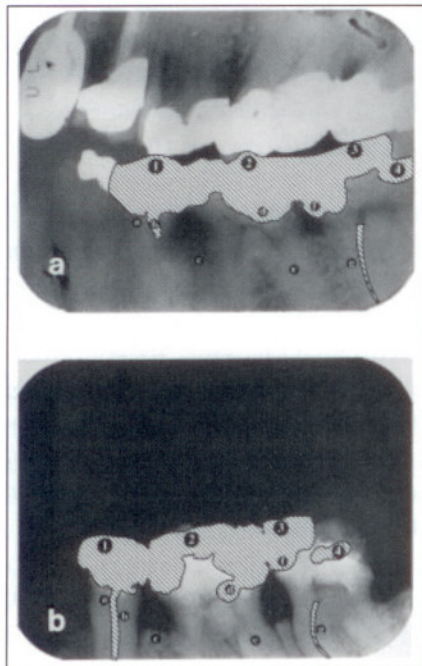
Contrasting features antemortem (top) and post-mortem radiographs as discussed in text
